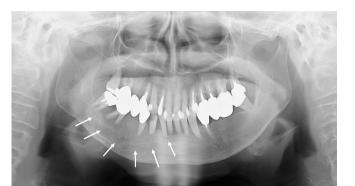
Panoramic radiograph showed a radiolucency with illdefined margin in the right mandible (arrows).
